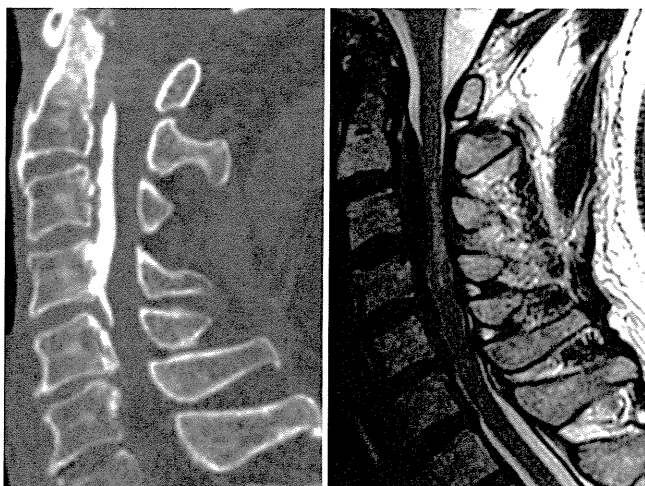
Case 2. Computed tomography scan (left) and MRI study (right) of the cervical spine. The MRI study shows a T2 high-intensity area in the spinal cord at the C3–4 level.
